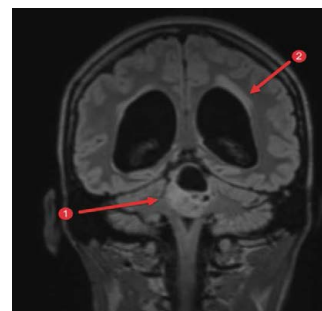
Preoperative T1-weighted coronal MR-image showing 1. Tumor with 4^e ventricle obstruction; 2. Enlarged lateral ventricles with transependymal CSF egress.
